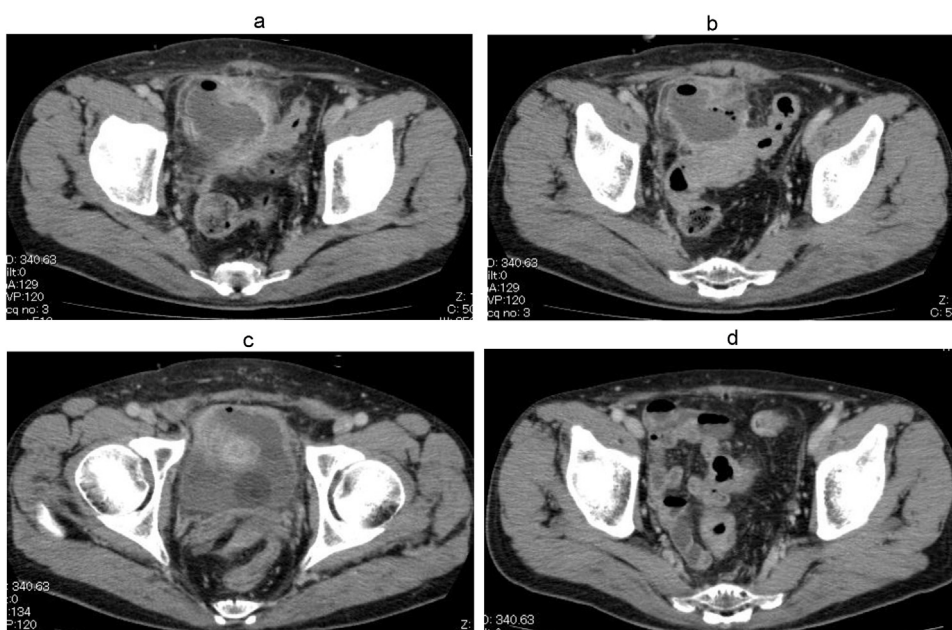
(a–c)Initial computed tomography showed a circumferential thickening of the sigmoid colon wall and involving urinary bladder with a pelvic abscess and urinary air (colovesical fistula). (d) After six courses of chemotherapy showed improvement of pelvic abscess and marked reduction of the tumor.
